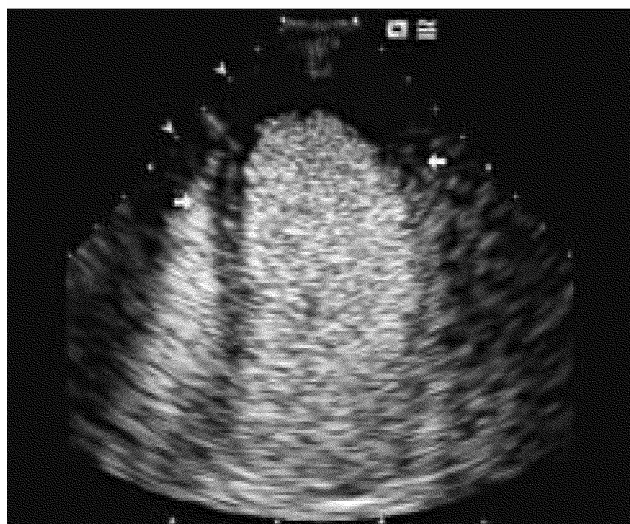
Myocardial contrast echocardiography showing (arrows) absent perfusion in the apex, indicating scar tissue.
